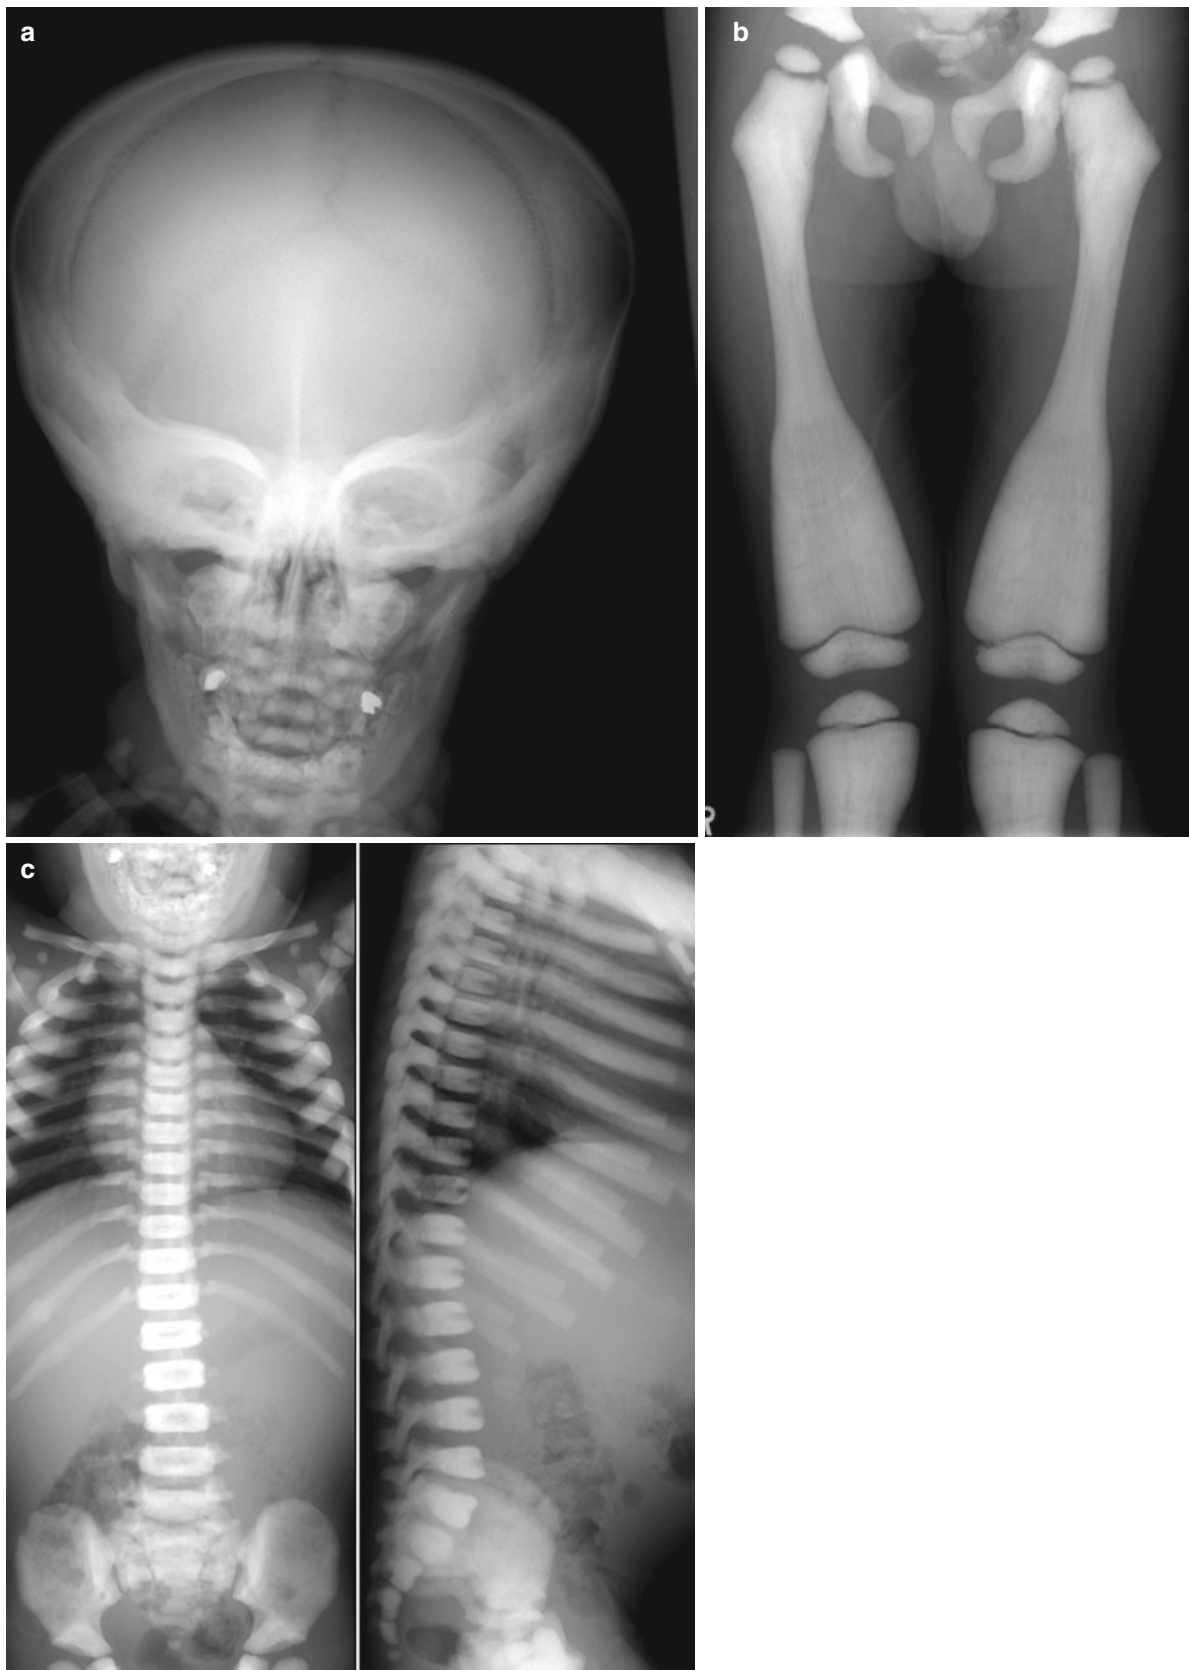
Osteopetrosis*. (a–c) Radiographs show overall increased density of the osseous structures due to the accumulation of immature bone. Note the undermodeling of tubular bones. Lateral spine radiograph shows the characteristic sandwich vertebra appearance
